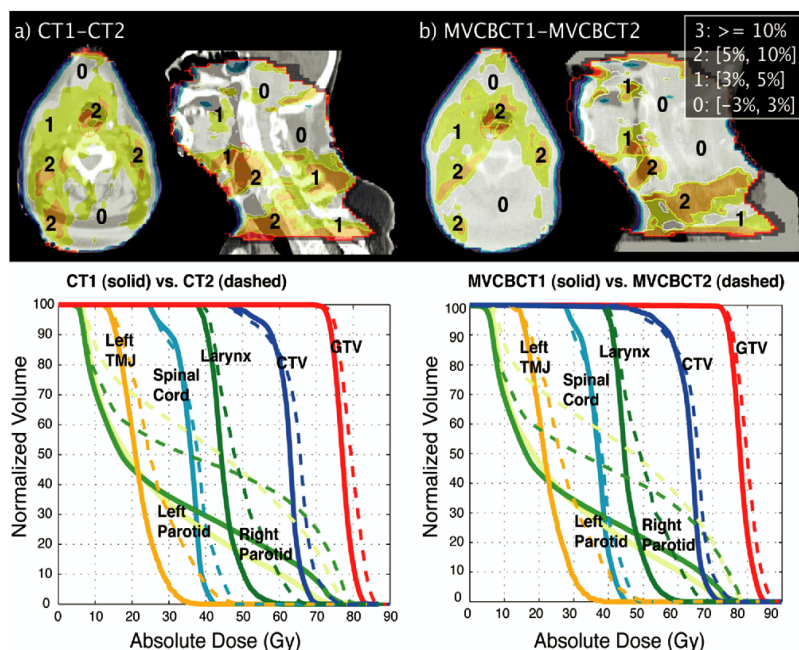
(Top) Axial and sagittal images crossing isocenter showing dose percentage difference distributions for (a) CT1 compared with CT2 and (b) MVCBCT1 compared with MVCBCT2. Large anatomic areas had the dose increased by  $\geq 5\%$ . These areas' locations were in good agreement between (Left) CT and (Right) MVCBCT. (Below) Dose-volume histogram (DVH) comparisons. All contours producing DVHs were drawn on CT images and applied to MVCBCT images after registration. Effect of weight loss on DVHs was very similar when calculated on either CT or MVCBCT.
